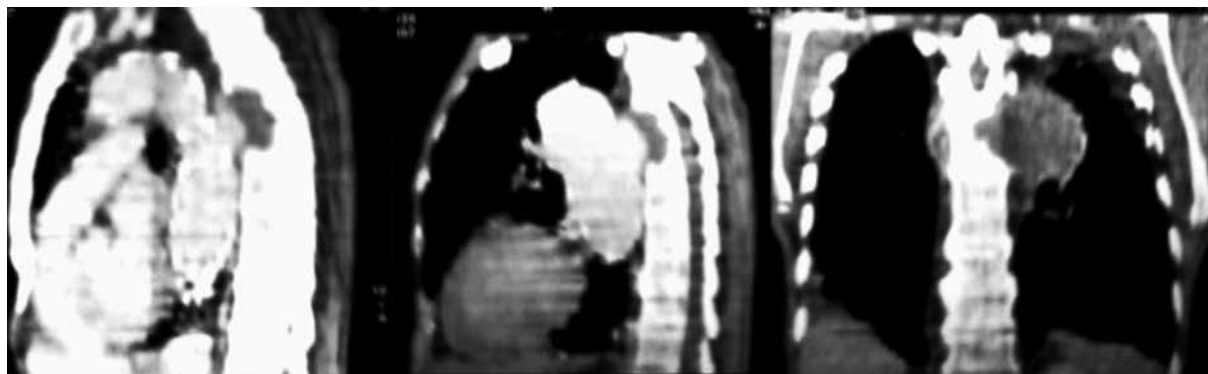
Thorax CT showing an aneurysmatic lesion of the descending thoracic aorta causing erosion of the vertebral bodies corresponding to T4 to T7.
